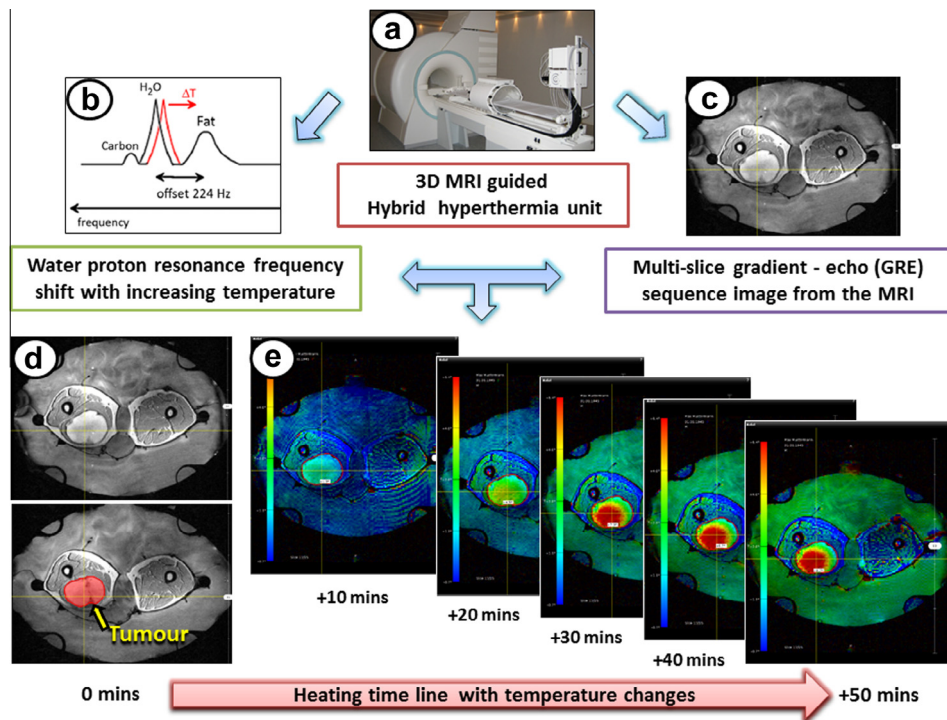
Noninvasive thermometry during hyperthermia treatment session using (a) 3D MRI hybrid hyperthermia unit. (b) This is based on the proton resonance frequency shift (PRFS) as tissue demonstrates a temperature dependent negative shift of the water PRFS at 1.5T. (c and d) The gradient-echo (GRE) images are obtained during the hyperthermia treatment session and the tumor is delineated. (e) Consequent images taken at each 10 min intervals from 0 to 50 min during hyperthermia. Each of the sequential images is subtracted from its predecessor to obtain a color wash image of the temperature distribution which is displayed in color scale. (Various elements used in this figure have been kindly provided by Dr. Sennewald, BSD Medical Corporation).
